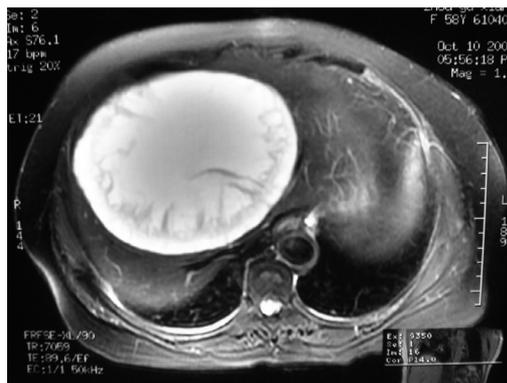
MRI (T2 weighted sequence) showing a huge cyst in the central liver with liquid content and flame-like prominences inside.
